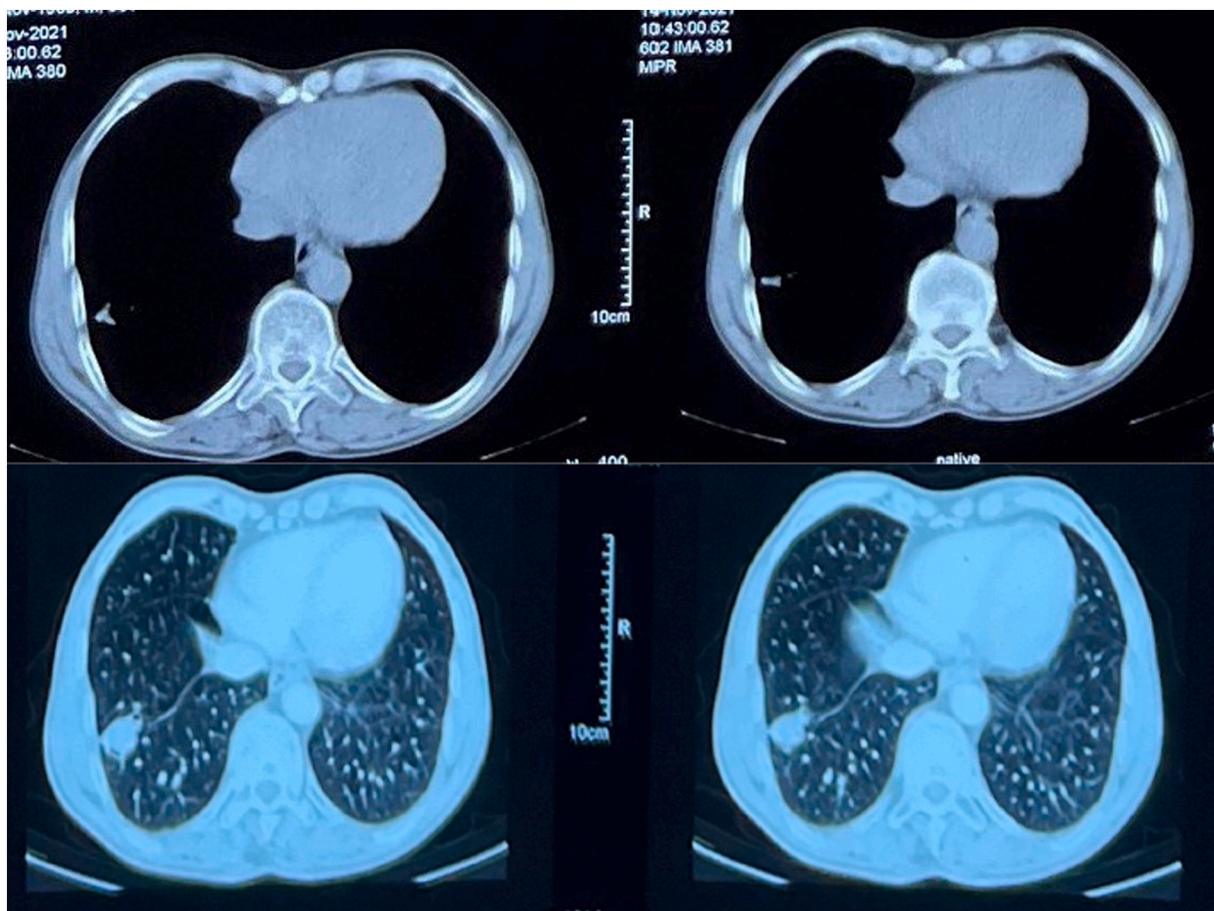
Axial view of the CT-scan shows a lesion in the right lower lobe.
